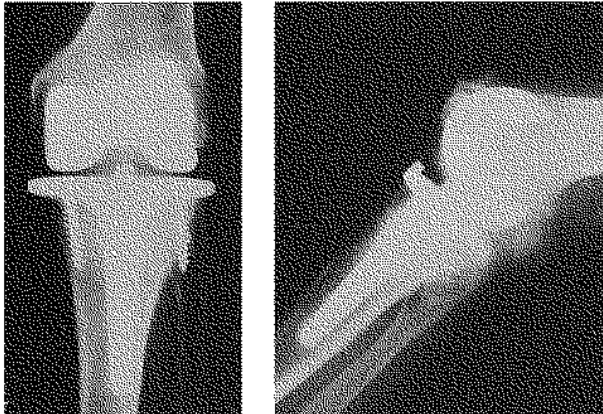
Anteroposterior (a) and lateral (b) radiographs of the infected total knee arthroplasty. No signs of loosening are present.
